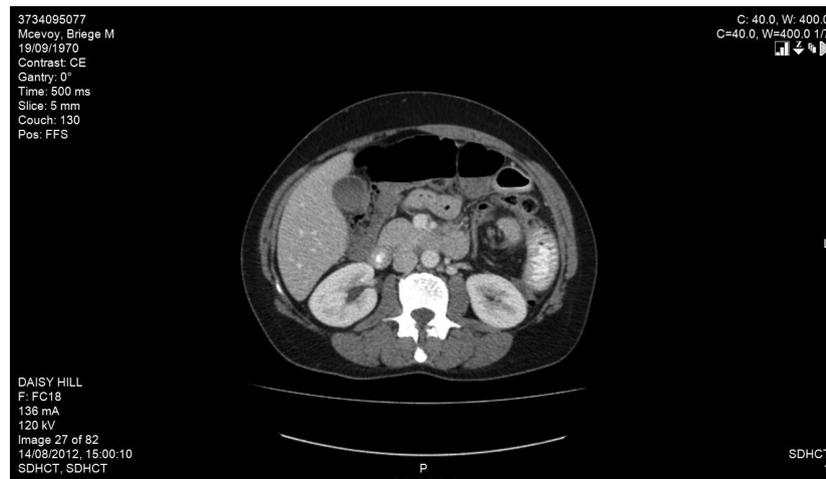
CT showing swirling of the vascular pedicle in keeping with splenic volvulus.
